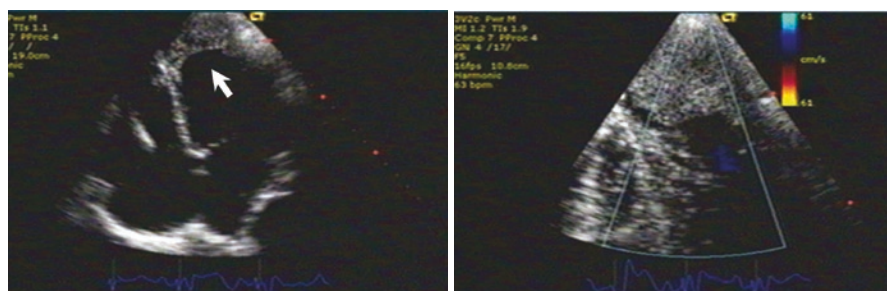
Apical four-chamber views of a transthoracic echocardiogram from a 74-year-old patient 3 months following AMI (top). Notice the large protruding apical thrombus (arrow). Color flow imaging (bottom) may be used to demonstrate abnormal flow patterns
